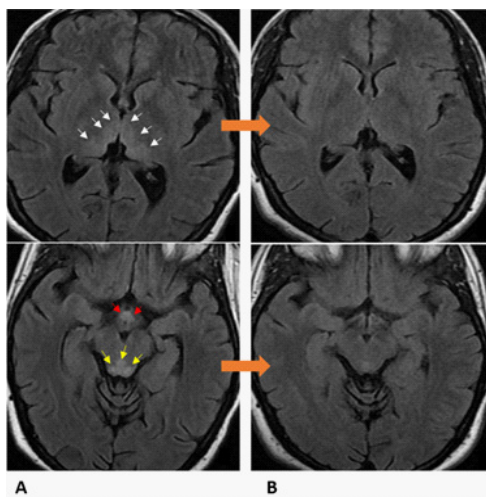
Axial Flair MRI showing (A) hyperintensity on both sides of the third ventricle extending to the thalamus (white arrows), at the periaqueductal (yellow arrows), alongside the mammillary bodies (red arrows), Control MRI 3 months after treatment showing (B) disappearance of the lesions described in the initial MRI.
